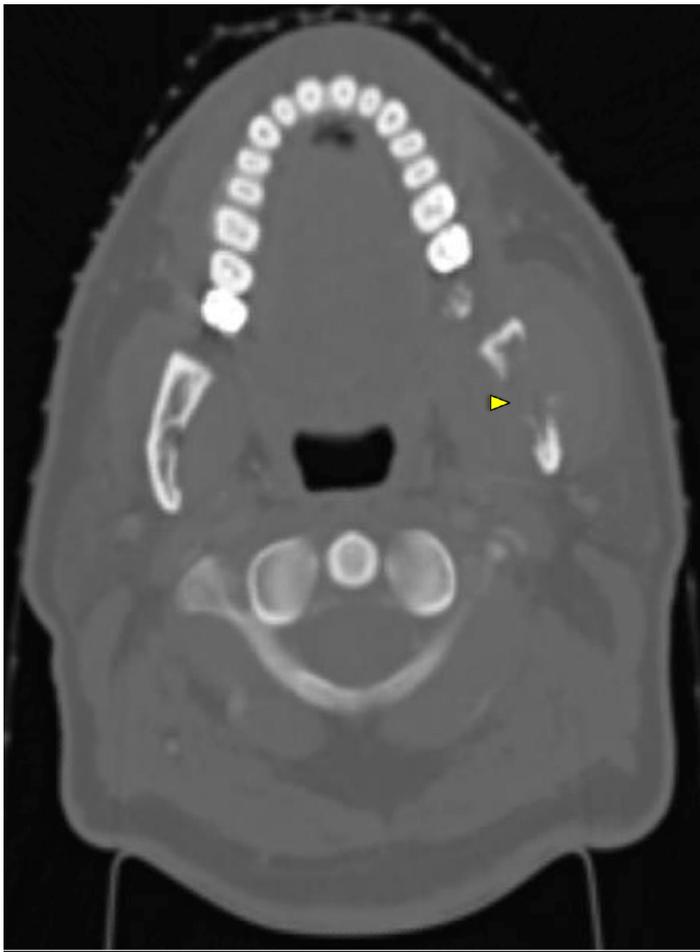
Axial CT with contrast in bone window display. Arrow signifies the left mandibular ramus lytic lesion with surrounding soft tissue edema.
